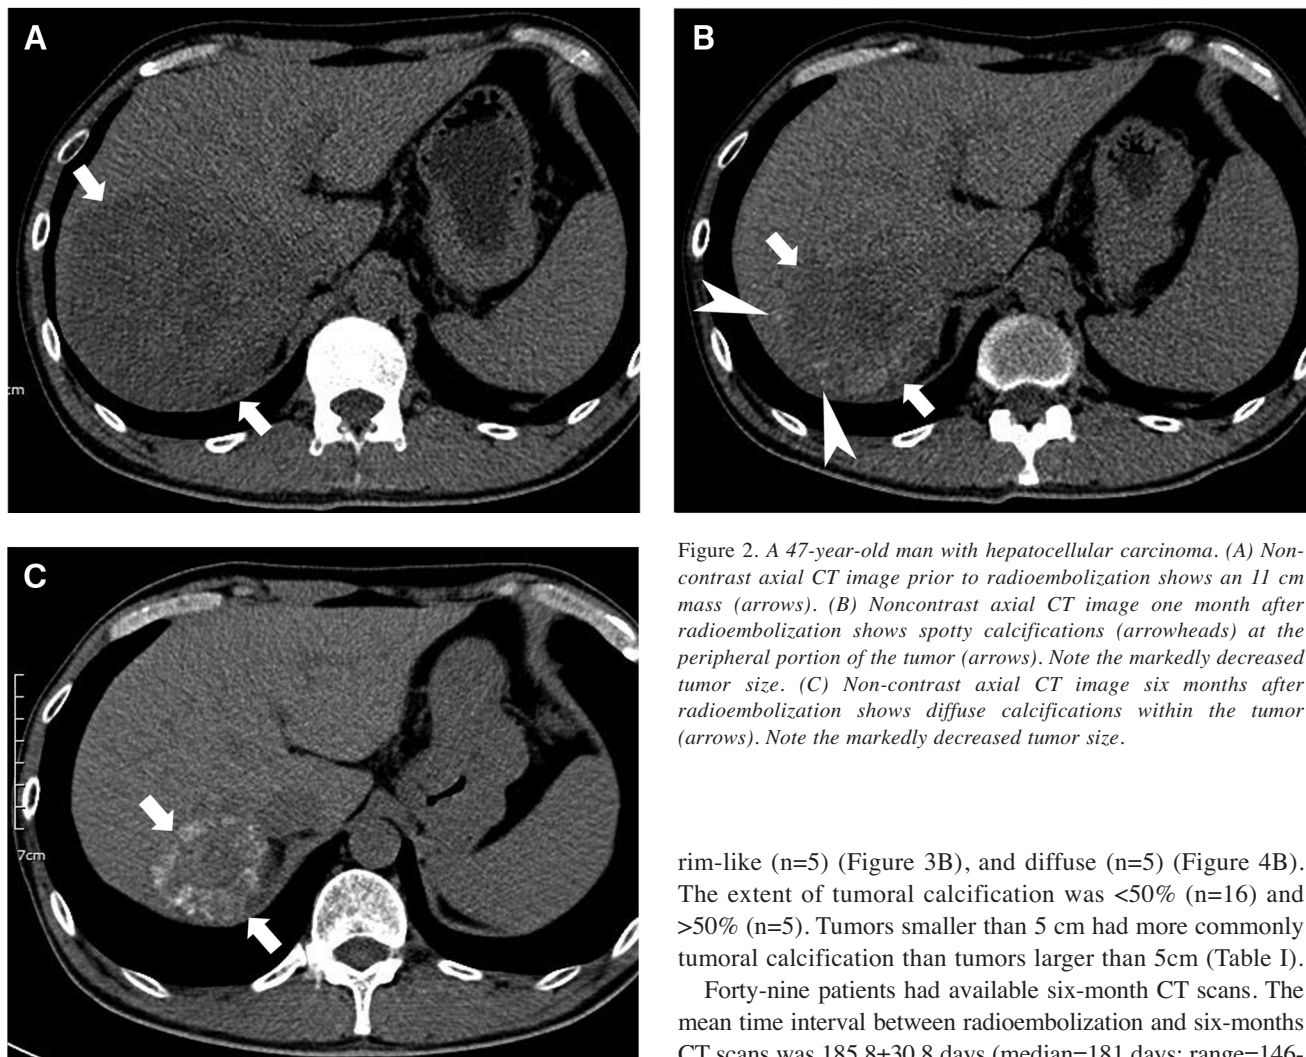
A 47-year-old man with hepatocellular carcinoma. (A) Non-contrast axial CT image prior to radioembolization shows an 11 cm mass (arrows). (B) Noncontrast axial CT image one month after radioembolization shows spotty calcifications (arrowheads) at the peripheral portion of the tumor (arrows). Note the markedly decreased tumor size. (C) Non-contrast axial CT image six months after radioembolization shows diffuse calcifications within the tumor (arrows). Note the markedly decreased tumor size.
